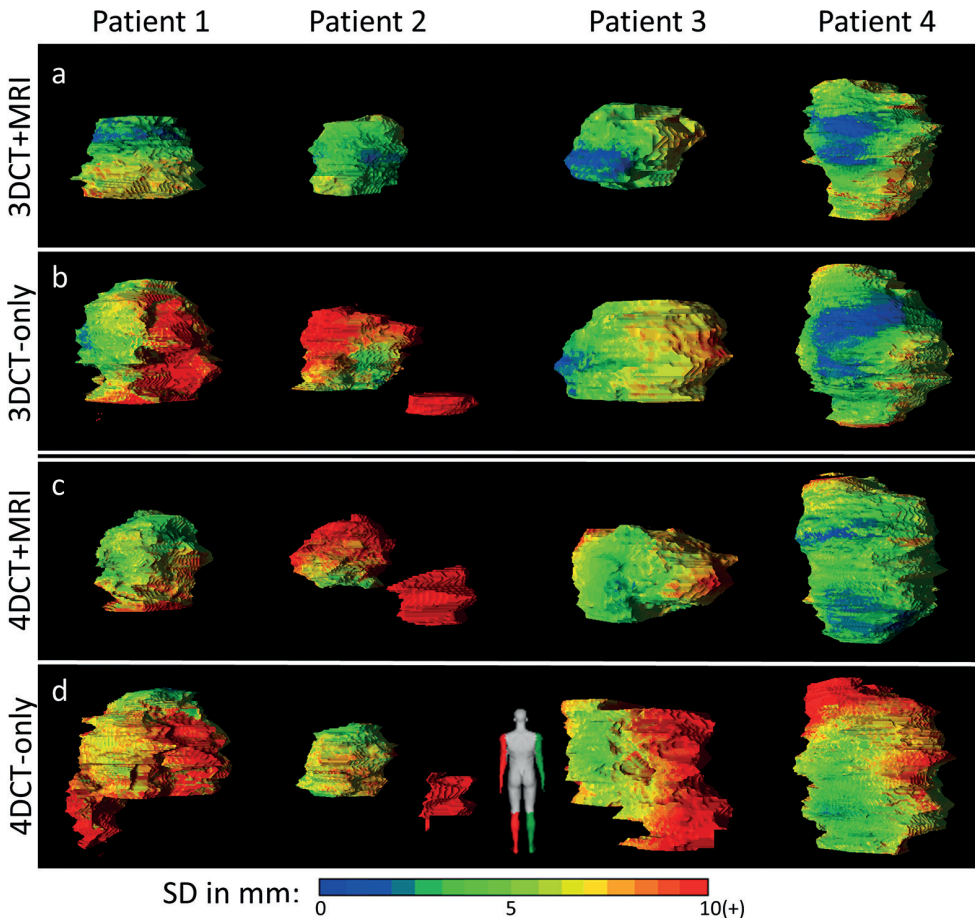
The local observer variation (local SD) projected on the median surfaces of the (i)GTV for 3DCT+MRI (a), 3DCT-only (b), 4DCT+MRI (c) and 4DCT-only (d). Colors correlate to the local SD, with red indicating local SD ≥ 9.4 mm. Volumes are viewed posterior of the patient (dummy). Note that for patient 2 the portocaval lymph node was included in (b-d). Figures (b) and (d) are from Versteijne et al [13].
